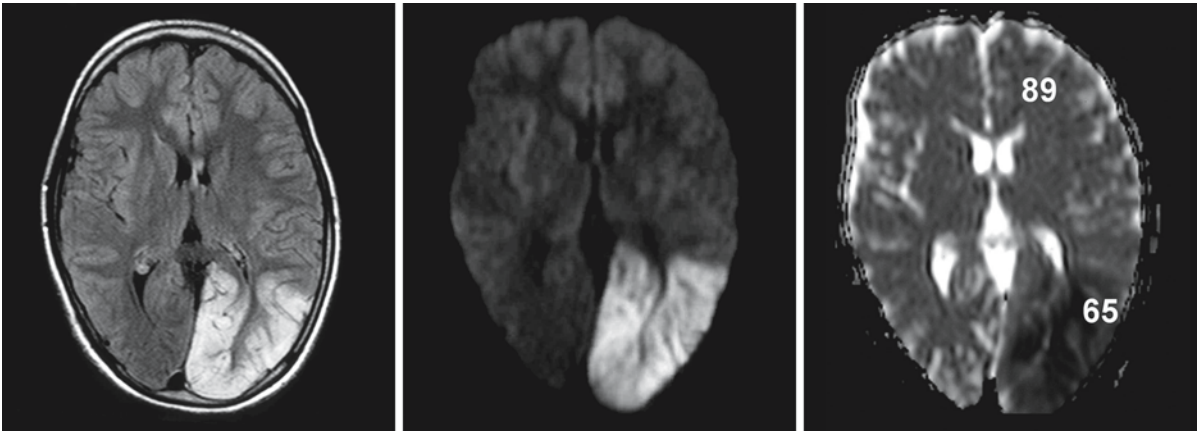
Conventional and diffusion-weighted MRI of a 13-year-old MELAS patient with the 3243 mitochondrial DNA mutation. The MRI was obtained 3 days after the onset of right-sided hemianopia. The FLAIR image (*left*) shows a large
